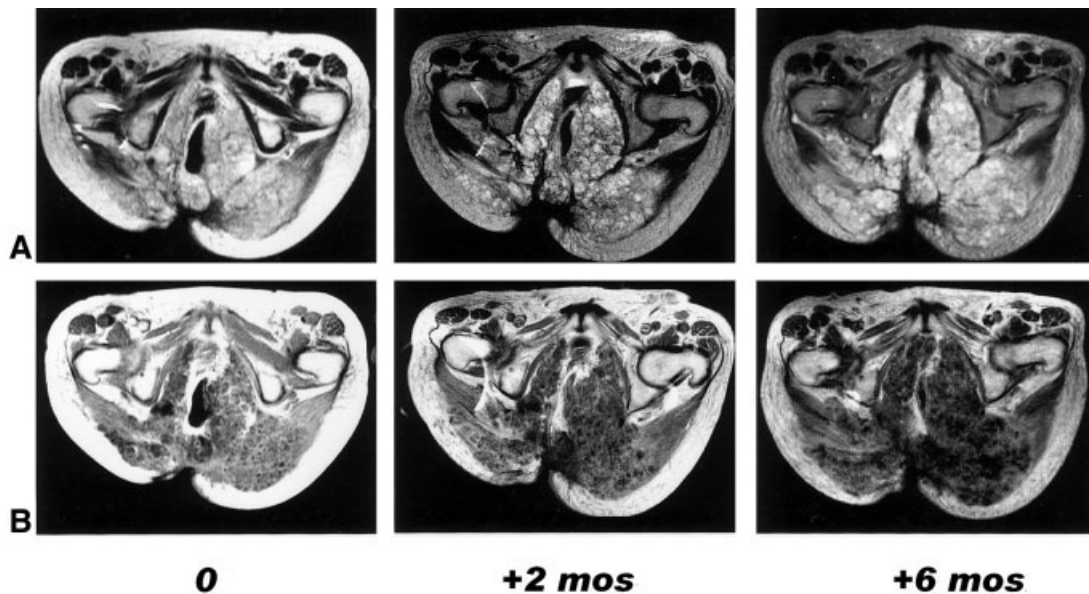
Magnetic resonance imaging in Patient 4. Some increase in size was visible in the first months of therapy, but it was accompanied by a higher signal on the T2-weighted images and a decreased contrast enhancement on T1-weighted images with contrast subtraction.
